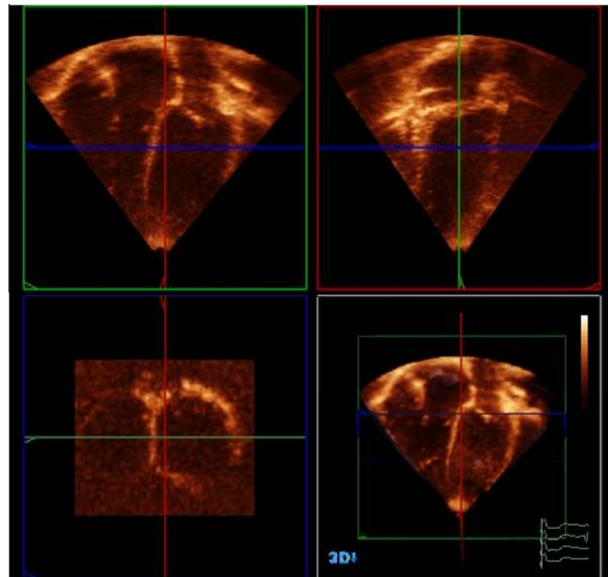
The acquired RTT-3DE datasets were stored on the machine's hard disk in the DICOM format. The datasets were analysed off-line with QLAB Advanced Quantification software (Philips Ultrasound, USA) installed in the IE-33 echocardiography machine (Philips, Bothell, Washington, USA). The MPR button is activated, and the echograph displays three colour-coded imaging planes (similar to 2DE planes) that move spontaneously. Any cardiac structure of interest to the operator (e.g. atrioventricular valves, intratrial or interventricular septa) can be evaluated individually by moving the colour-coded bar, and the structure of interest can be evaluated in the corresponding colour-coded box. The fourth plane showed a full 3DE image (in the lower right quadrant).
